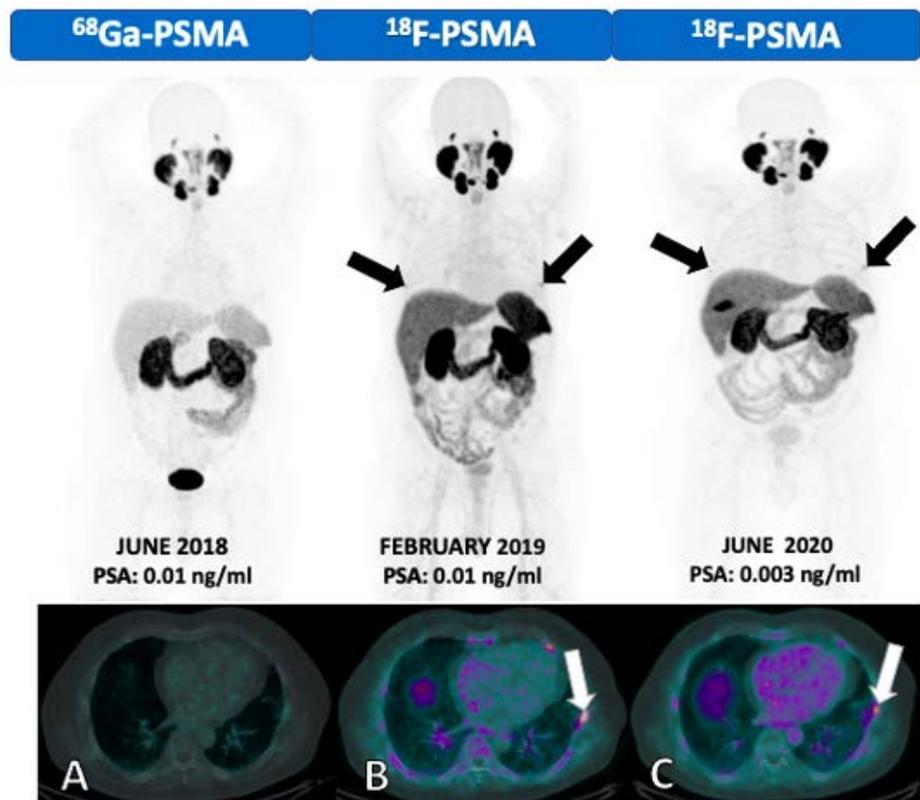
Follow-up of a patient with a history of prostate cancer (A) MIP in anterior and PET/CT in axial fusion with ⁶⁸Ga-PSMA performed in June 2018 without evidence of abnormal uptakes (B) Follow-up carried out in February 2019 with ¹⁸F-PSMA where minimal focal uptake is observed in the sixth bilateral costal arch with SUV_{max} of 3.5, the PSA at the time of the study was 0.01 ng/ml. (C) PET/CT with ¹⁸F-PSMA performed in June 2020, the focal uptakes in the costal arches continue with minimal uptake and without significant changes in size, the PSA at the moment of the study was 0.003 ng/ml.
